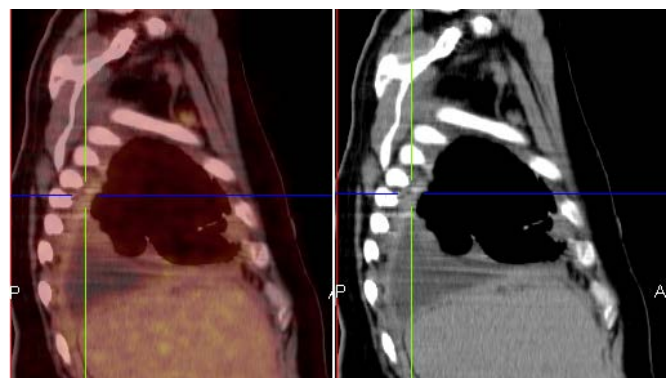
Case example showing BPT and BPE cytopathology results. Sagittal fused 18F-FDG PET/CT and CT images of a 48-year-old male smoker without asbestos exposure who has diffuse pattern pleural thickening and PE. Pleural thickening SUVmax 1.74
